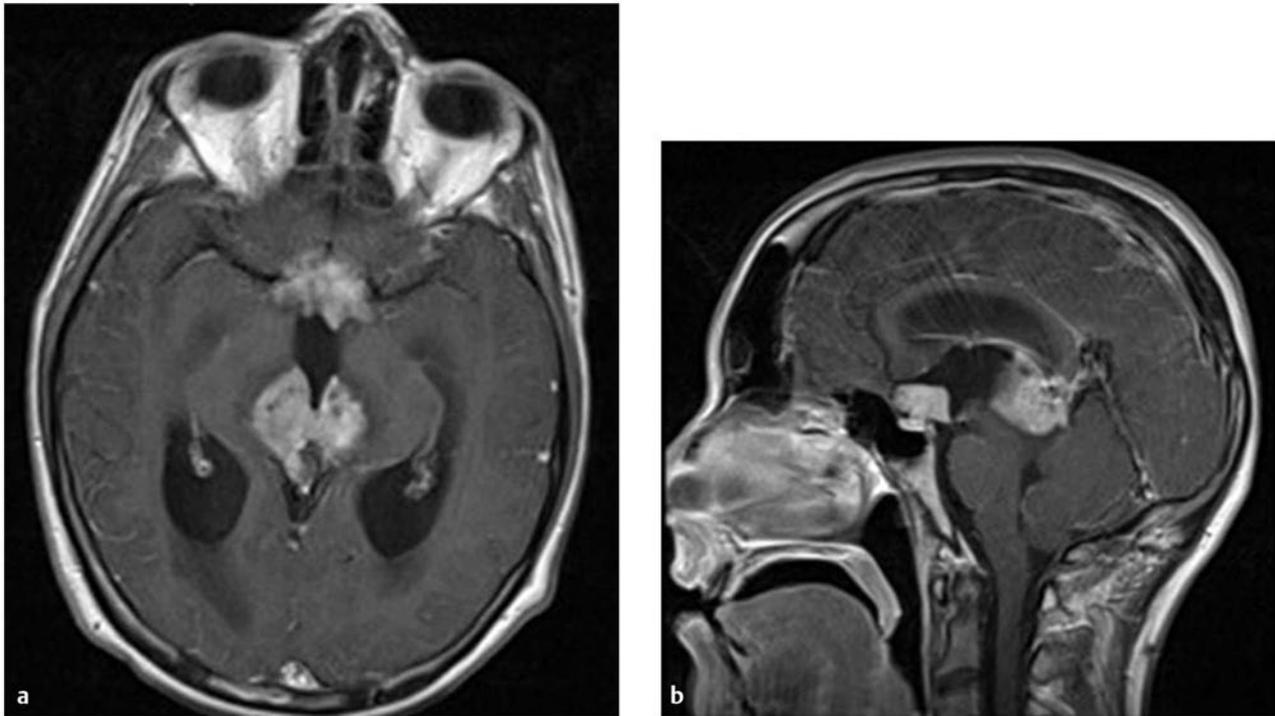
(a) Axial and (b) sagittal magnetic resonance images after contrast infusion showing concurrent germ cell tumors with elevated serum alpha fetoprotein in the pineal and suprasellar locations.
